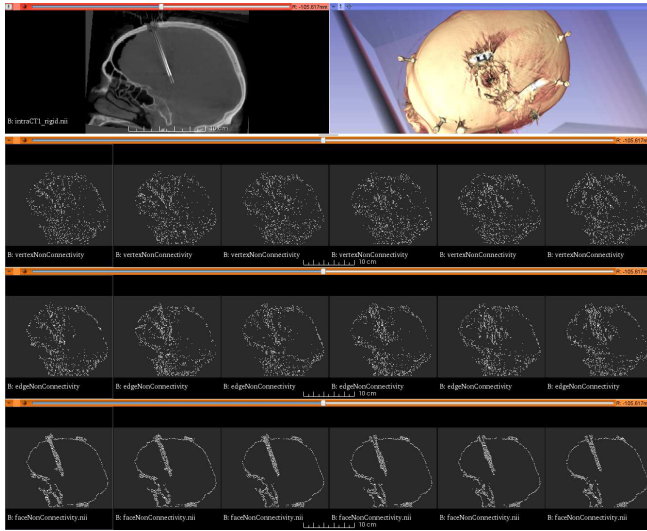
The distribution of the selected blocks in a brain CT scan, using different connectivity patterns. The results are depicted on six consecutive slices. From top to bottom row: sagittal CT slice (left) and volumetric rendering (right), selected blocks with “vertex” connectivity, selected blocks with “edge” connectivity, selected blocks with “face” connectivity. The “vertex” pattern results in a more uniform distribution, while the “face” pattern results in a higher block density nearby the lead and the tissue boundaries.
